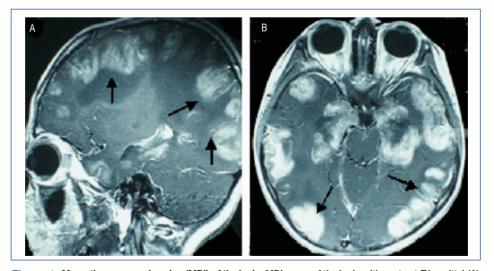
Magnetic resonance imaging (MRI) of the brain. MRI scans of the brain with contrast-T1 sagittal (A) and axial (B) views show multiple non-homogeneous, hypodense masses along the bilateral cortex as indicated by arrows.
